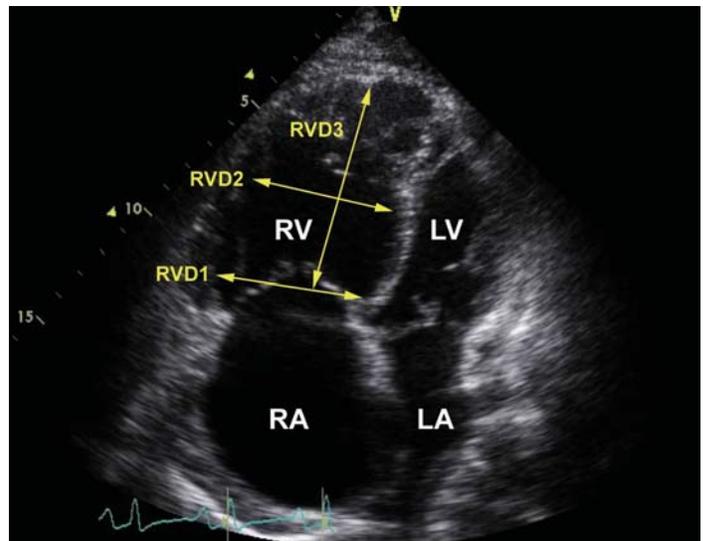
Right ventricular diameters in the apical 4-chamber view. Right ventricular size can be quantified by obtaining the basal (RVD1), midcavity (RVD2), and longitudinal (RVD3) diameters in the apical 4-chamber view at end diastole.¹ Normal diameters for the right ventricle are: RVD1: 2.0-2.8 cm, RVD2: 2.7-3.3 cm and RVD3: 7.1-7.9 cm.¹ In this patient with pulmonary hypertension, the right ventricle is hypertrophied and the pump function is severely impaired with marked enlargement of the right ventricle and right atrium and impression of the left ventricle and left atrium.
